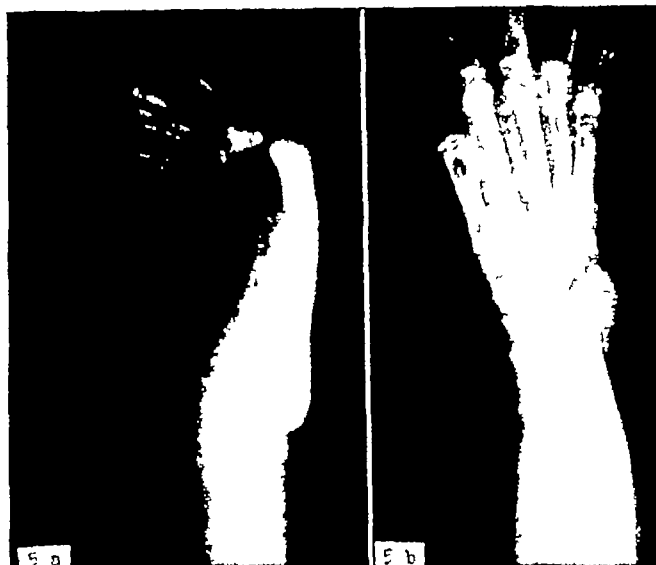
Reconstruction of congenital absence of the radius with autogenous fibular bone graft. a Preoperative X-ray of the right hand shown in fig 402a. b X-ray of the same forearm taken one year after autogenous fibular bone graft.
